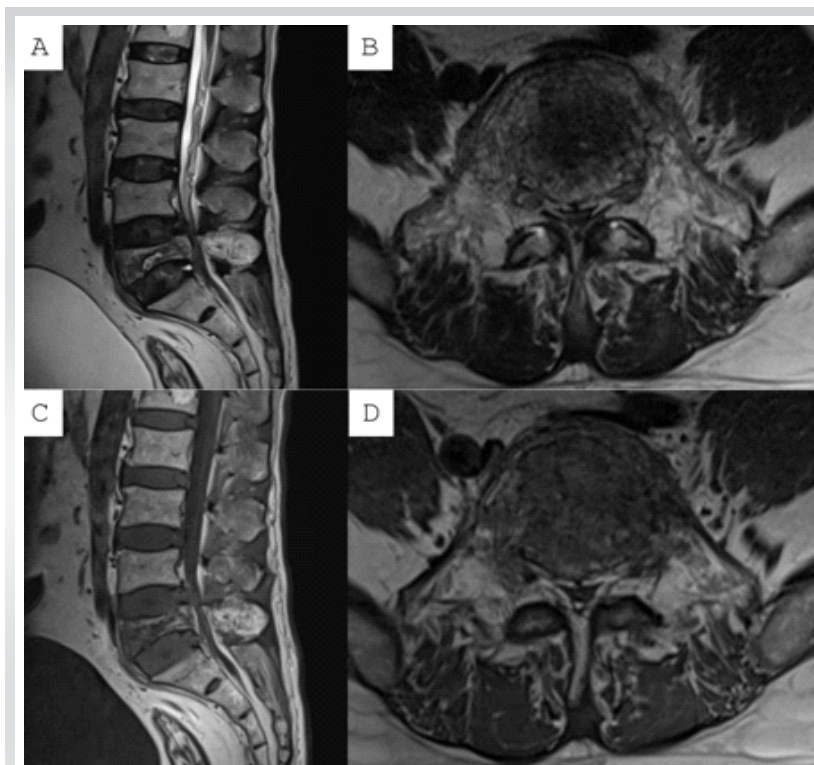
Sagittal and axial magnetic resonance imaging (MRI) showing L5 pathological fracture with thecal sac compression on T2-weighted MRI (a and b) and T1-weighted MRI (c and d).
